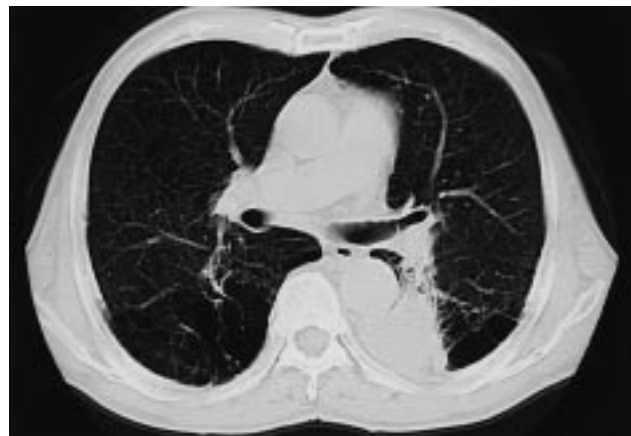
Chest CT scanning in the carinal level shows a large mass shadow suggesting lung cancer in the left S6 area.
